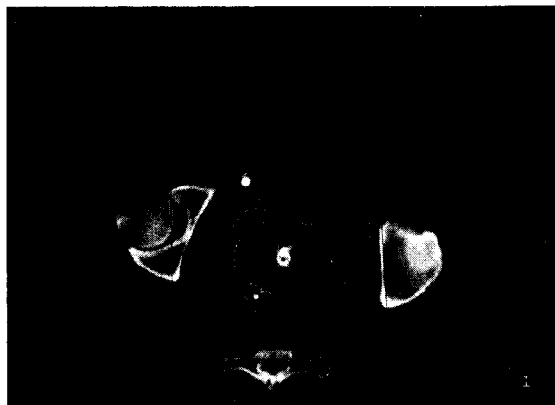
Isodose distribution on CT image
